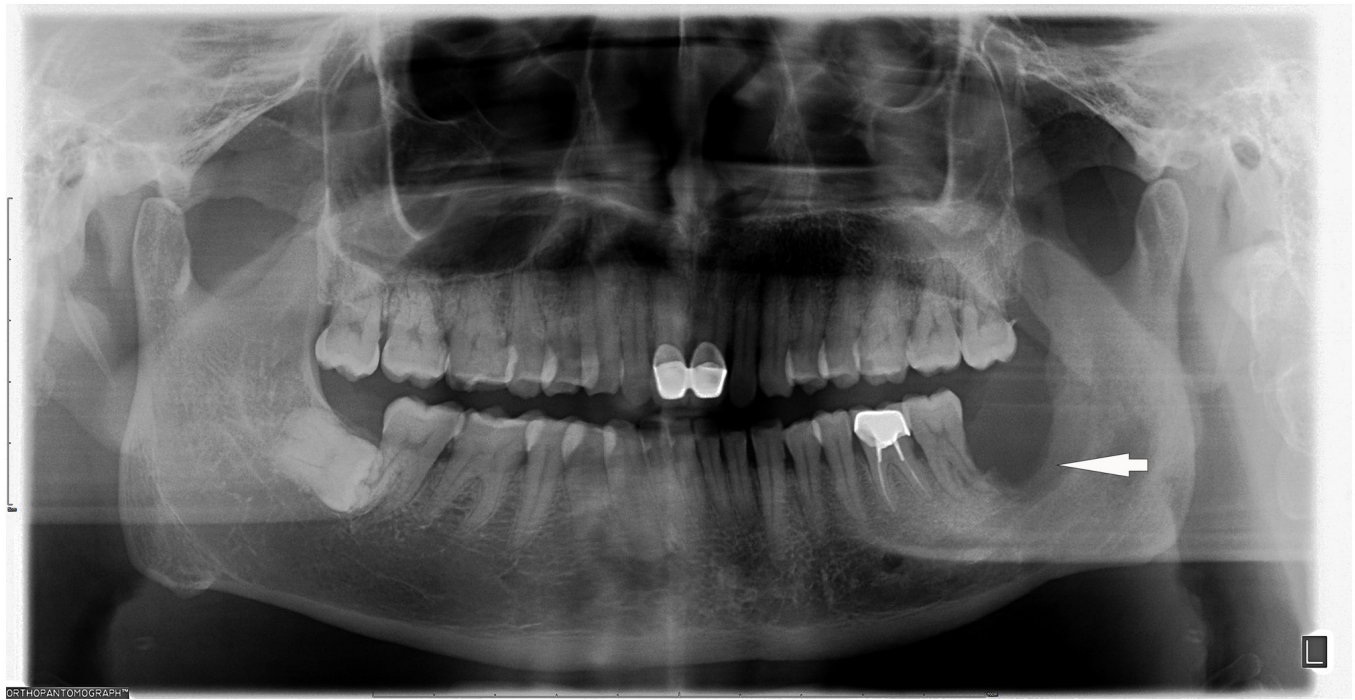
Panoramic radiograph prior to admission. The lower left third molar was missing, with resorption of the alveolar socket extending to the root apex area of the lower left second molar. In addition, a 0.5x1 cm low-density shadow with an indistinct boundary was discernible in the middle and lower portion of the left mandibular ascending branch (arrow).
